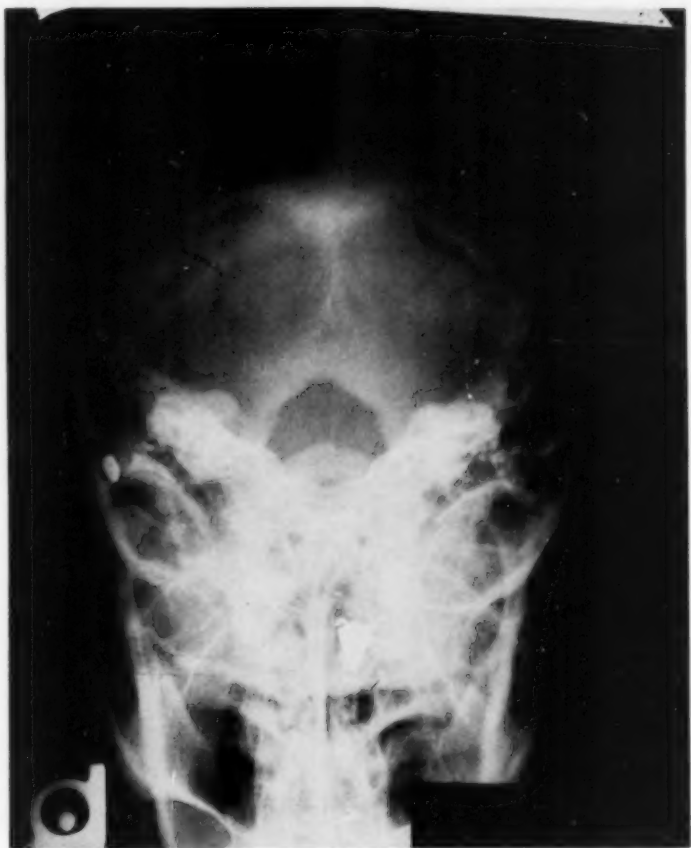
Roentgenogram of mastoids in Towne position showing Diodrast in the air space between the tumor and the tympanic membrane. The circular opacity is a lead disc lying against the lateral surface of the tumor.
